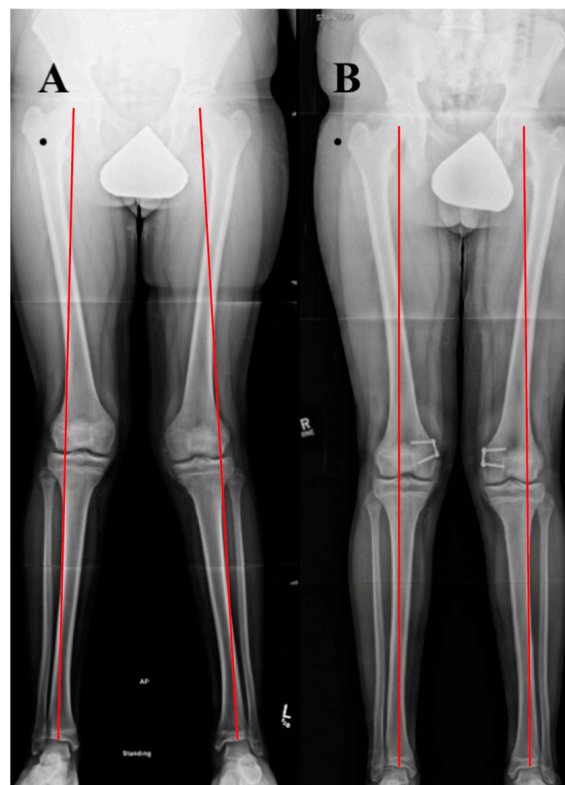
Case example of growth modulation. A 14-year-old male with right patellar instability who underwent bilateral guided growth (hemiepiphyseodesis) for genu valgum using a plate and screw construct over the medial distal femoral epiphysis. (A) A standing alignment radiographic preoperatively with Grade III bilateral genu valgum. (B) A 6 month postoperative standing alignment demonstrating correction of coronal plane malalignment.
